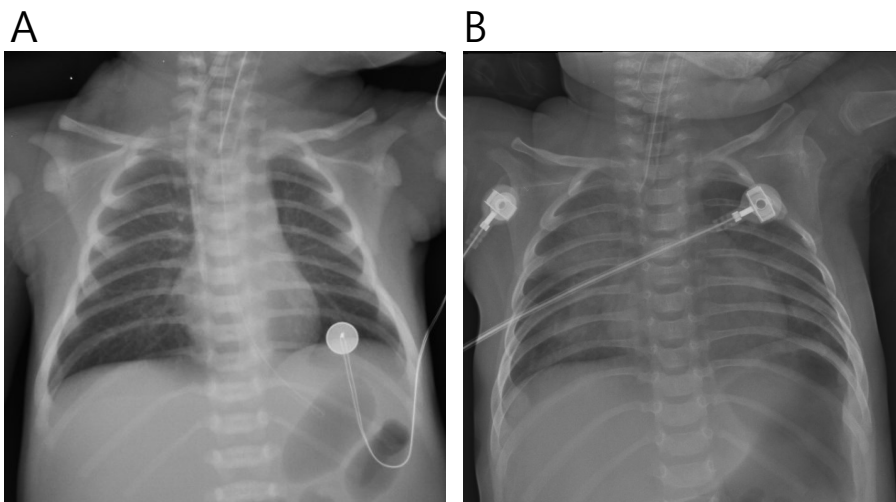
Antero-posterior chest radiographs of the patient. (A) Initial chest radiograph shows no abnormal findings with cardiothoracic ratio of 0.41 at 3 days of age. (B) On the day of cardiopulmonary arrest, chest radiograph demonstrates cardiomegaly with cardiothoracic ratio of 0.56 and pulmonary infiltrates on both lung fields, which were thought to be secondary changes due to resuscitation.
